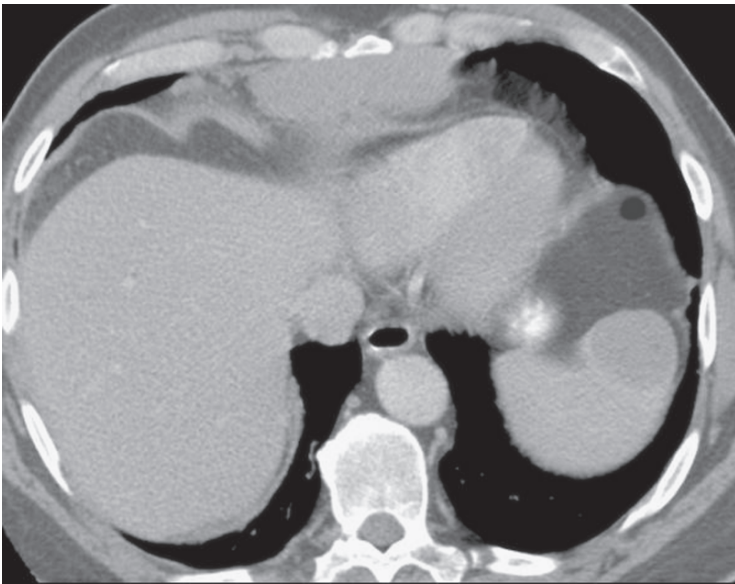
Axial CT image in a 30-year-old patient showing a solitary hypodense mass in the spleen. This proved to be a Hodgkin's lymphoma
